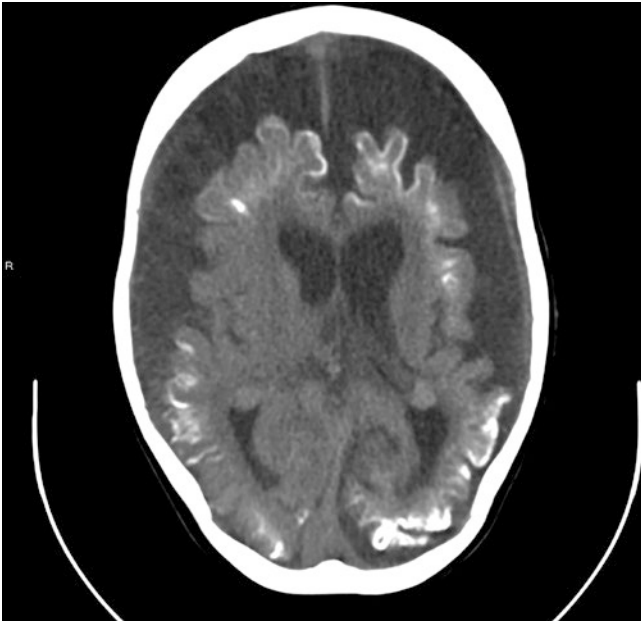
Axial CT image of brain in a patient with Sturge-Weber syndrome, showing bilateral gyriform subcortical calcification. Both cerebral hemispheres are atrophic
